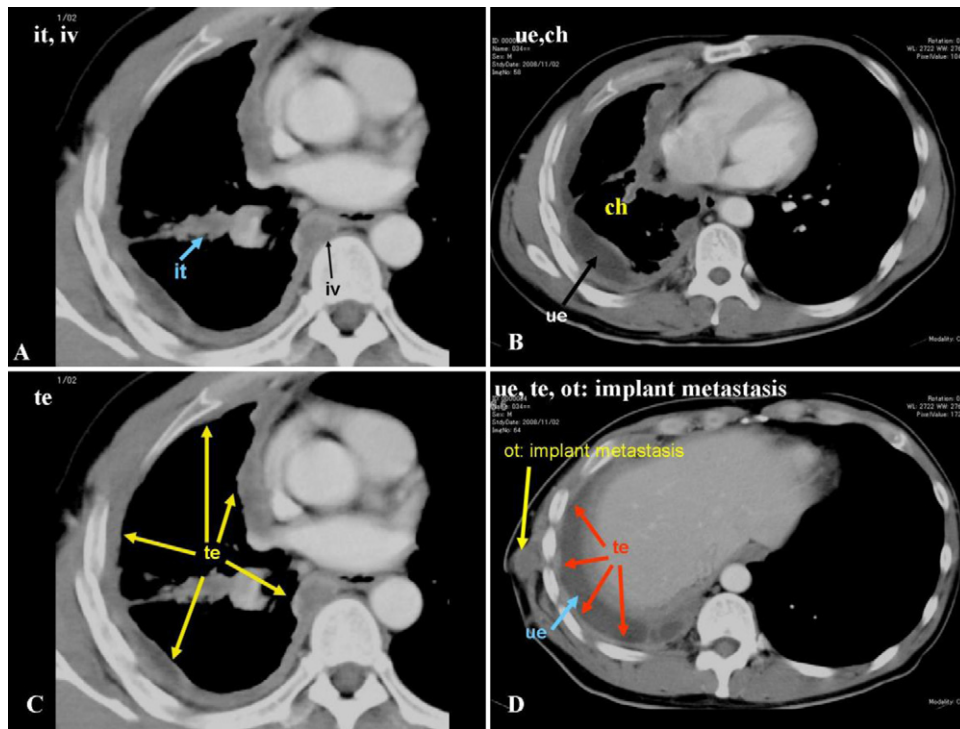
A 45-year-old man with diffuse epithelioid MPM. CT scan shows interlobar fissure pleural thickening (A), invasion to the tissue near to the vertebral column (“iv”) (black arrow) (A). There is unilateral pleural effusion (“ue”) (black arrow) on the right hemithorax, leading to the contracted hemithorax (“ch”) (B). Tumoral encasement of lung (“te”) involvement on the right hemithorax (C, D) and an implant metastasis lesion are observed on the chest wall of right lung (D). According to the CT appearance, MPM probability was agreed by experts as high probability Grade 4 at advanced severity. This is a typical MPM case.
